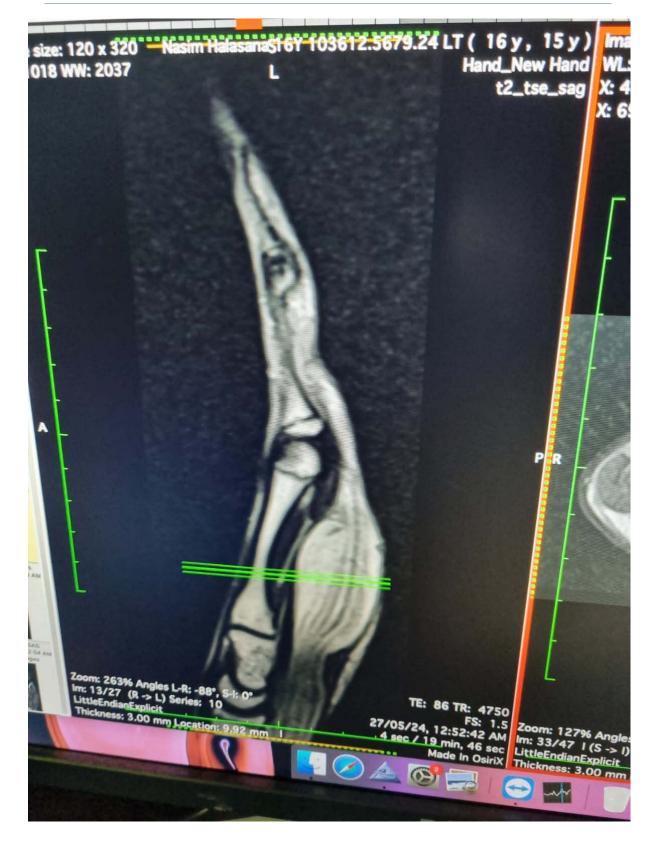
Magnetic Resonance imaging of Lipofibromatous Hamartoma with coaxial cable-like appearance
